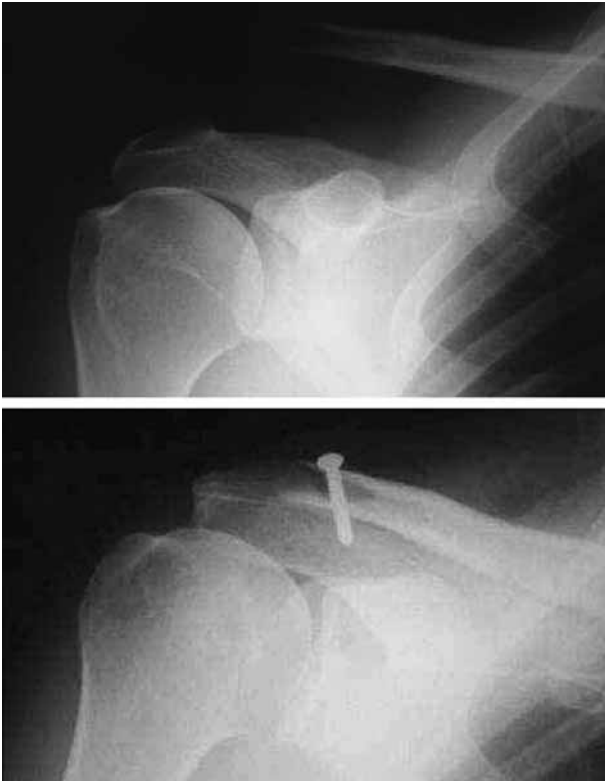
Pre-operative and post-operative x-rays
